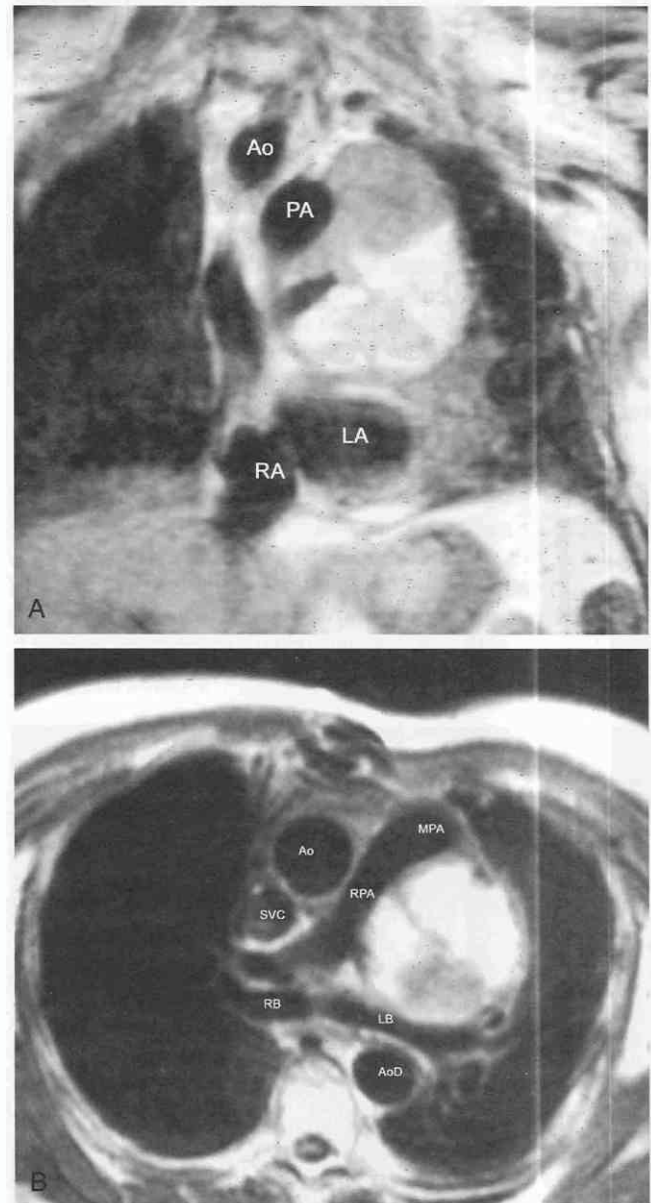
MR images of recurrent pericardial sarcoma in a 58-year-old man. A, Coronal spin-echo acquisition shows this 15 × 20 cm inhomogeneous mass elevating and displacing the main pulmonary artery (PA), the right pulmonary artery (RA), and the ascending aorta (Ao). LA, left atrium. B, Axial section through the displaced right pulmonary artery (RPA) again shows the mass sitting on the roof of the left bronchus (LB). Ao, ascending aorta; AoD, descending aorta; MPA, main pulmonary artery; RB, right bronchus; SVC, superior vena cava.
